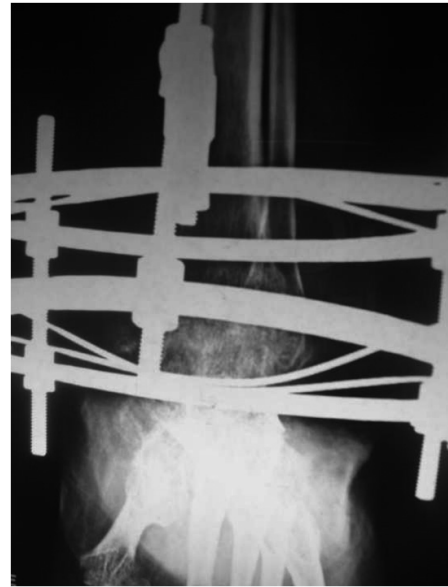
Intra operative AP and lateral radiographs with Ilizarov ring fixator in place
